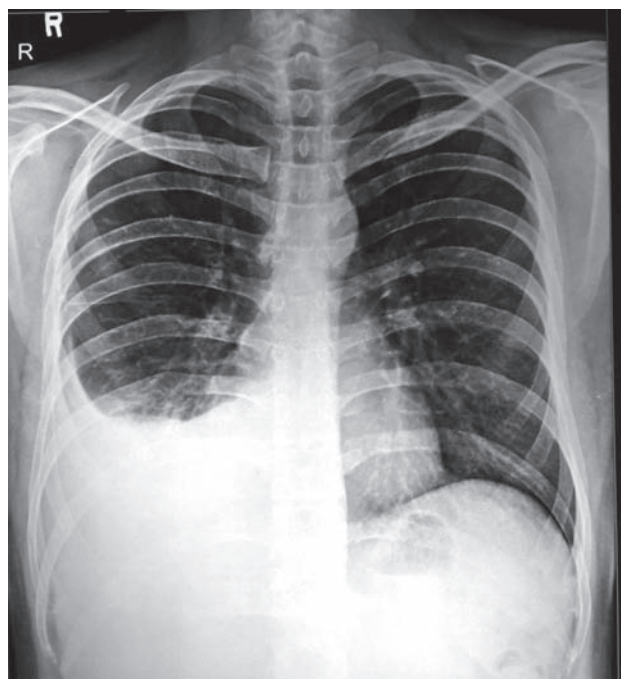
Chest X-ray after 1 month showing pleural effusion.
